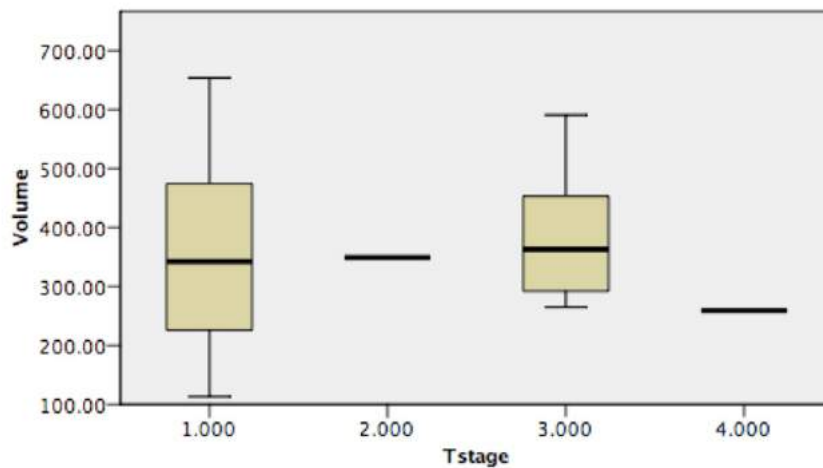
Relationship between clinical T-stage and measured pleural tumour volume at contrast-enhanced MRI
